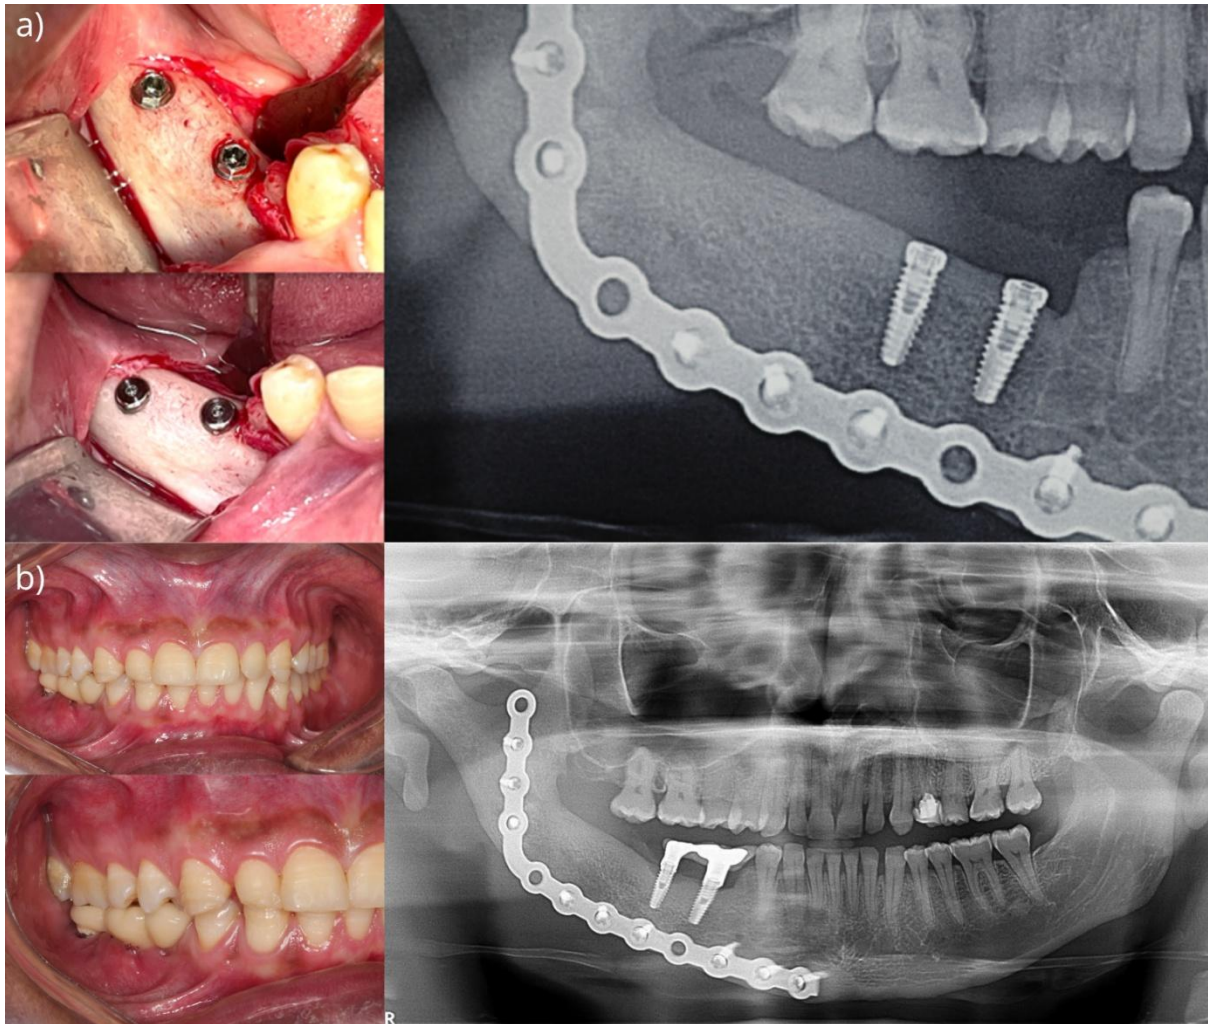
a) Transoperative photos and postoperative panoramic radiography of the installation of two titanium implants. b) Intraoral photos and panoramic radiography after installation of the implant-supported prosthesis.
